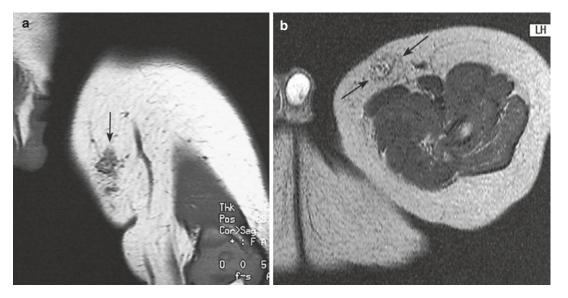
(a, b) Fibrous hamartoma in a 6-month-old boy. (a) Coronal spin-echo T1-weighted MR image. (b) Axial spin-echo T2-weighted MR image. On the T1-weighted image, the lesion presents as an ill-defined, inhomogeneous mass of intermediate signal intensity
